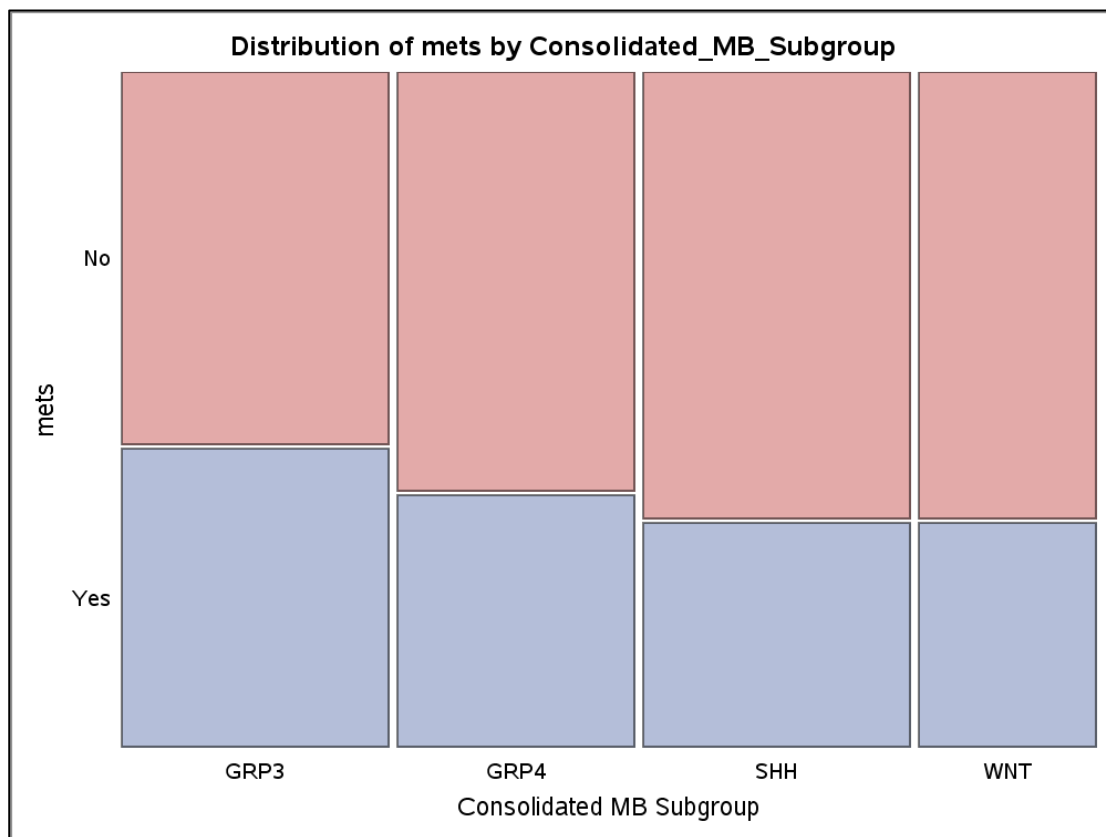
Metastasis and its incidence between the molecular subtypes. Metastasis was identified either by the patient MRI imaging report or by CSF malignant cells at 2 weeks or follow up post operatively.
